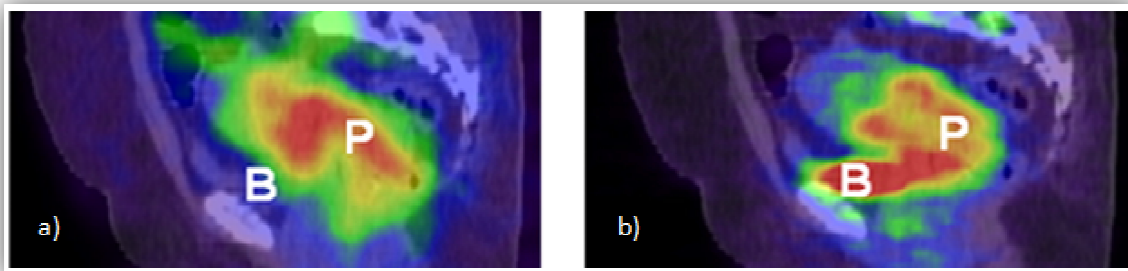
Sagittal reconstructions from the same hypoxic tumour. a) ^{18}F -FDG PET/CT image, showing an intense ^{18}F -FDG uptake in the known primary cervical tumour (P). b) CU-ATSM PET/CT image, at the same level, also shows an increased tracer uptake. Note that there are different uptake patterns between the two tracers. B = Urinary bladder (48).
